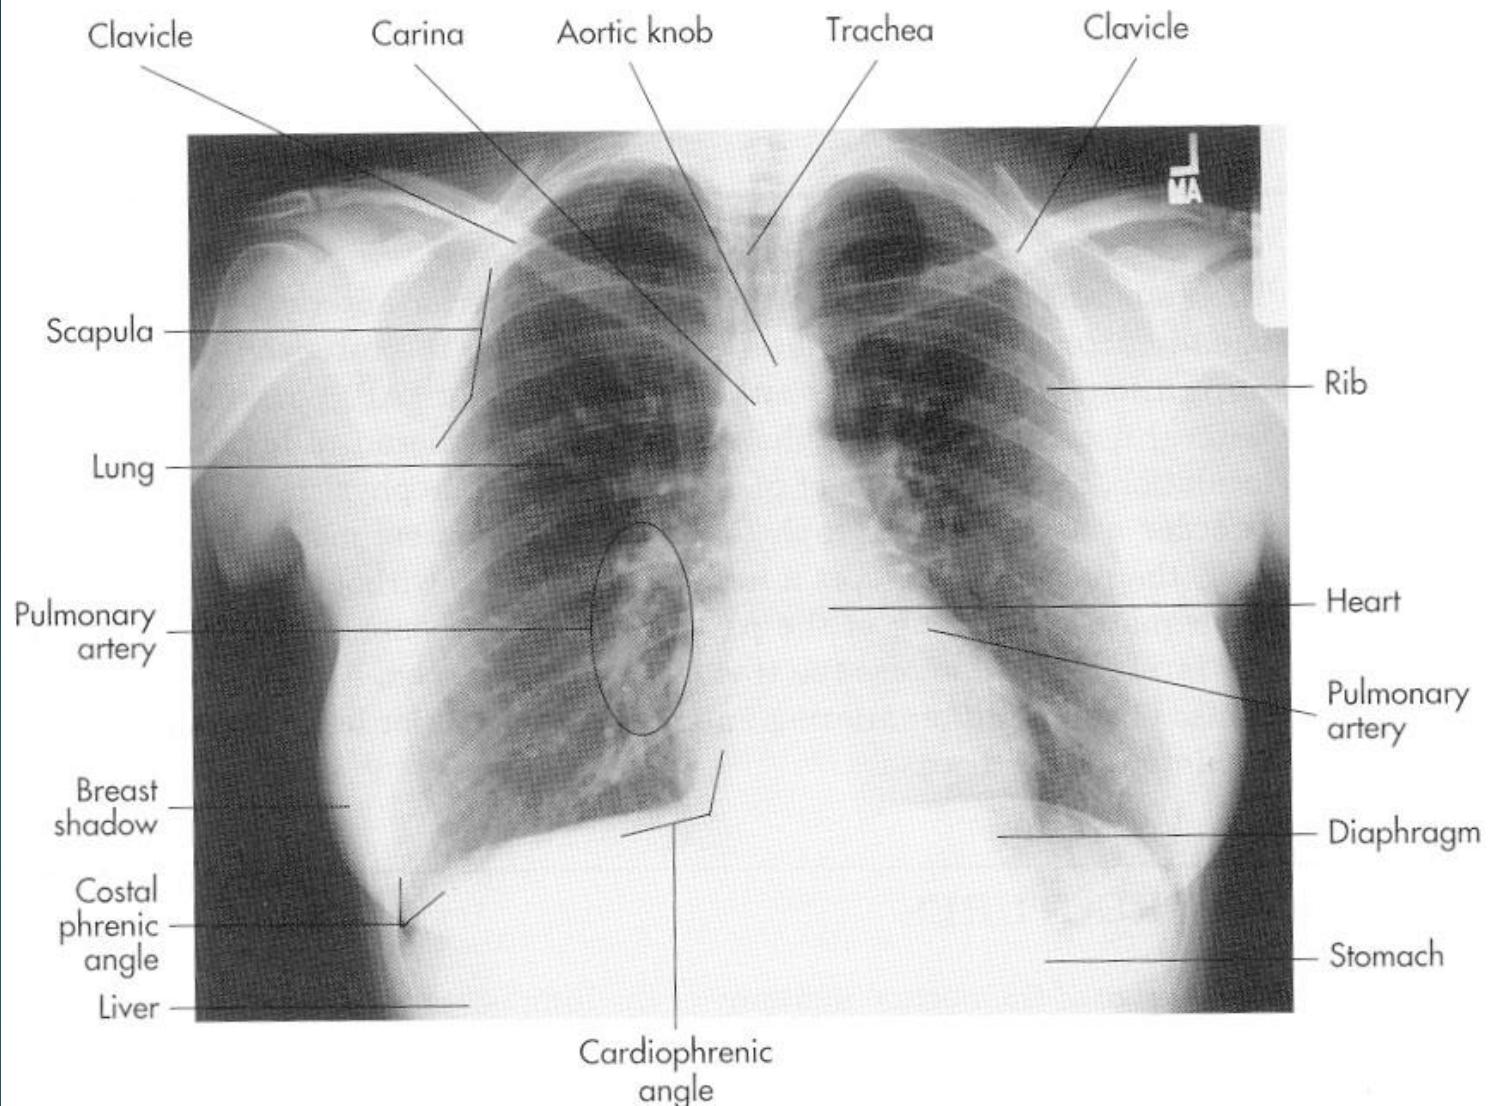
Normal position of anatomical structures on a posterior or anterior chest radiograph.
